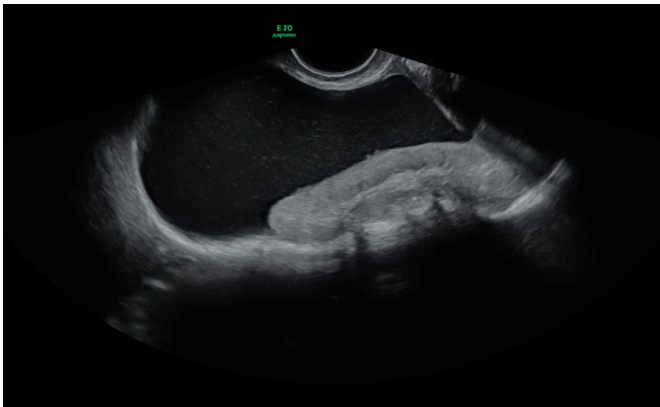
Gray-scale ultrasound, suspicion bladder tumor.
